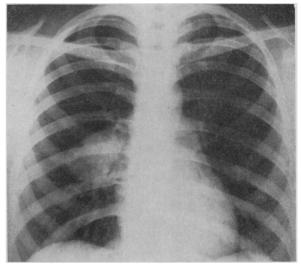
Posteroanterior chest roentgenogram taken in 1945; patient aged 20 (21 years before admission).
